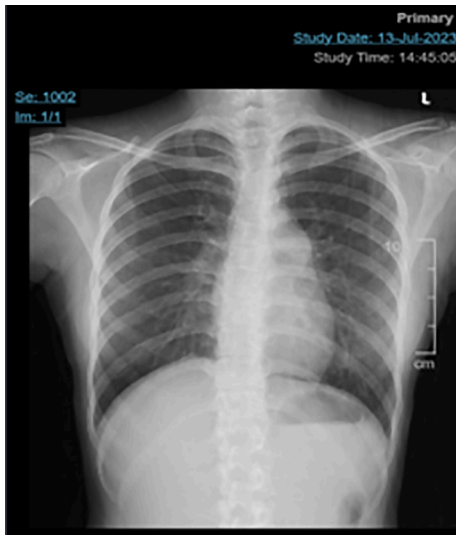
Chest X-ray examination of this patient.
